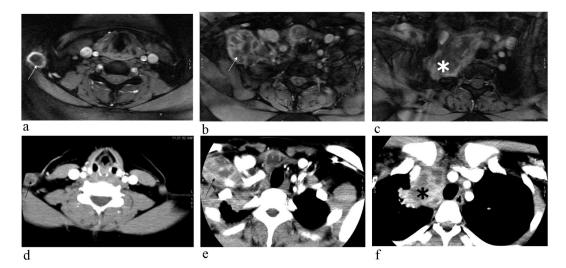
Post gadolinium MRI of the neck and upper thorax in axial sections (first row a-c) in comparison to contrast enhanced CT (second row d-f). There are multifocal lesions seen in the right superficial cervical region (arrows) and deep mediastinal lesions (asterisks).
